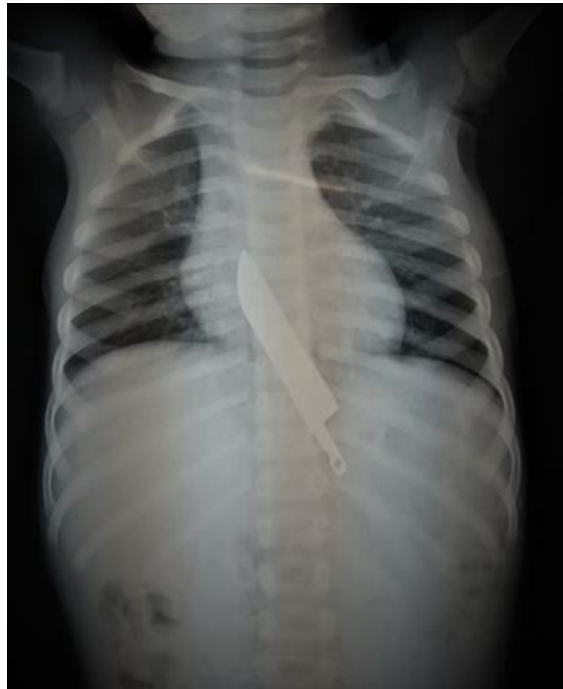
Plain abdominal x-ray showing the metal part of the knife in the esophago-gastric junction
